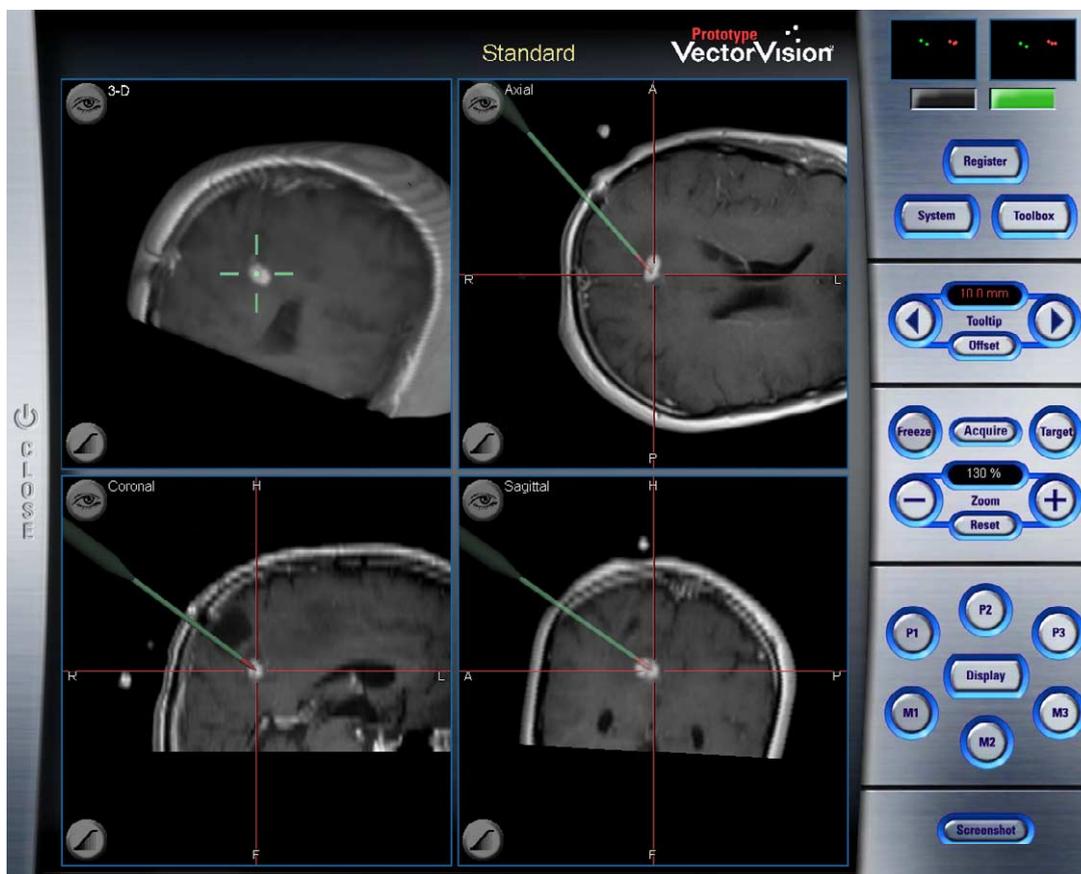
Screen capture of multiplanar gadolinium-enhanced T1-weighted intraoperative magnetic resonance images showing trajectory planning. 3D = 3-dimensional.
